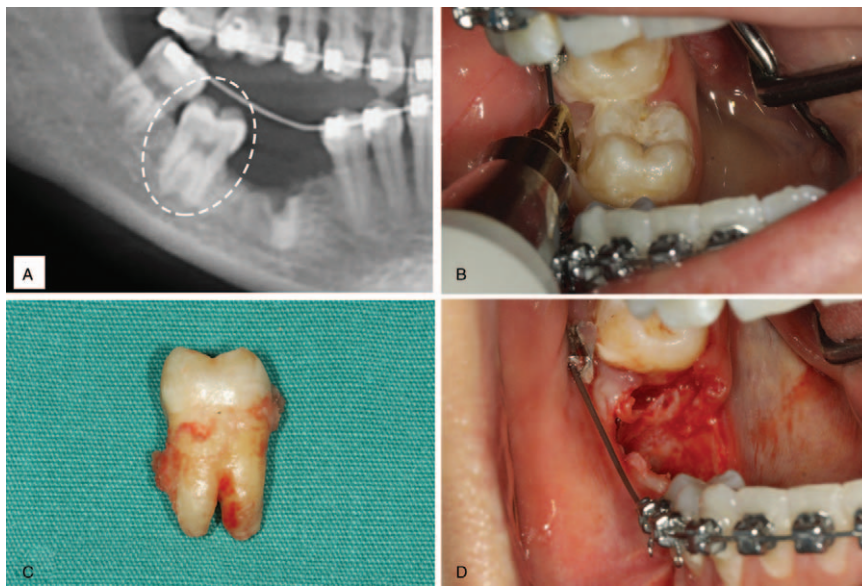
Extraction of ankylosis teeth. (A) Tooth #47 should be removed based on orthodontic needs because this tooth failed to orthodontic traction. The radiographical examination showed that the dark continuous lines between tooth #47 and the alveolar bone, which represents periodontal ligament, were missing. (B) Piezosurgery was used to create space on the buccal, lingual, mesial, and partial distal aspects of tooth #47, and the tooth was removed by forceps. (C) The removed teeth were intact. (D) No alveolar bone fracture and soft tissue injury occurred during the surgery.
